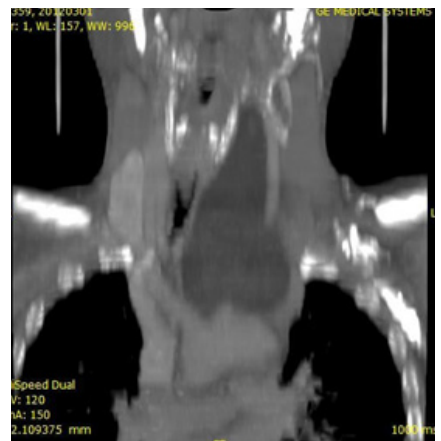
Coronal reconstruction of CT showing left anterior neck lipoma extending up to the mediastinum.
